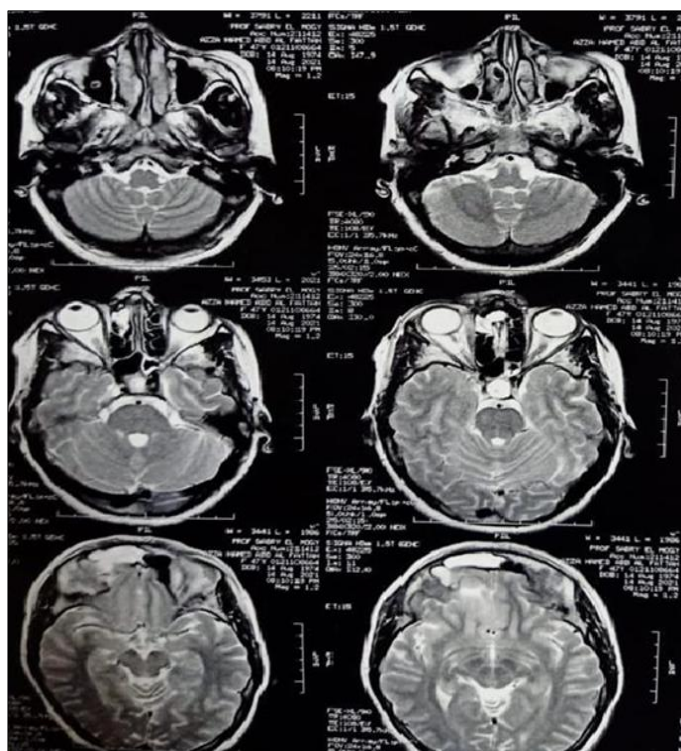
a male cases aged 75- y with DM presented with facial tingling following 17 days of COVID-19 infection. Axial T2 weighted MRI at level of nasopharynx showing high signal / hyperintense lesion in the Rt frontal lobe
